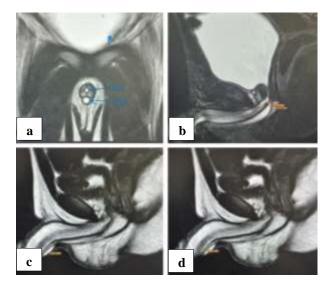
(a) Coronal view of T2 weighted images of MRI showing B- bladder, DU-dorsal urethra, and VU-dilated ventral urethra; (b) mid sagittal view of T2 weighted MRI image showing bifurcation of urethra in sphincteric zone; (c) mid sagittal view of T2 weighted MRI image showing diameter of ventral urethra in glans area is 1.79 mm; and (d) mid sagittal view of T2 weighted MRI image showing distance between dorsal and ventral urethra in glans area is 2.23 mm.
